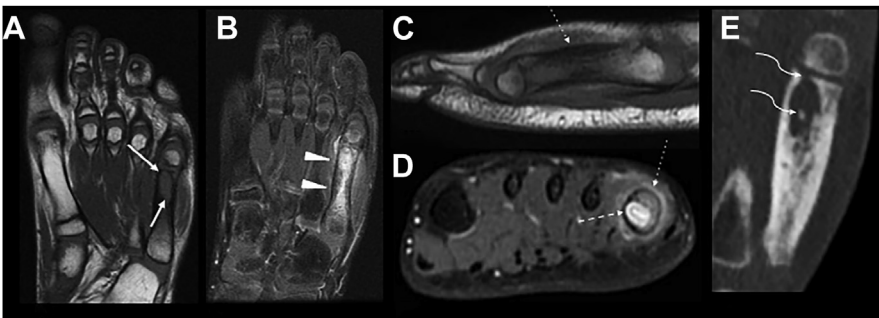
Bacterial osteomyelitis. A 7-year-old girl presenting with pain and swelling of the forefoot. MR images (axial T1 (A), axial T2FS (B), sagittal T1 (C), and coronal T1FS after gadolinium injection (D)) showing bone marrow edema (arrowheads) and intraosseous abscess with the penumbra sign (arrows) on the distal metaphysis of the fifth metatarsal, with a solid corticoperiosteal reaction (dotted arrows) and enhancement (dashed arrows). CT scan (E) showing a bony sequestrum and extension to the distal physis (curved arrows).
